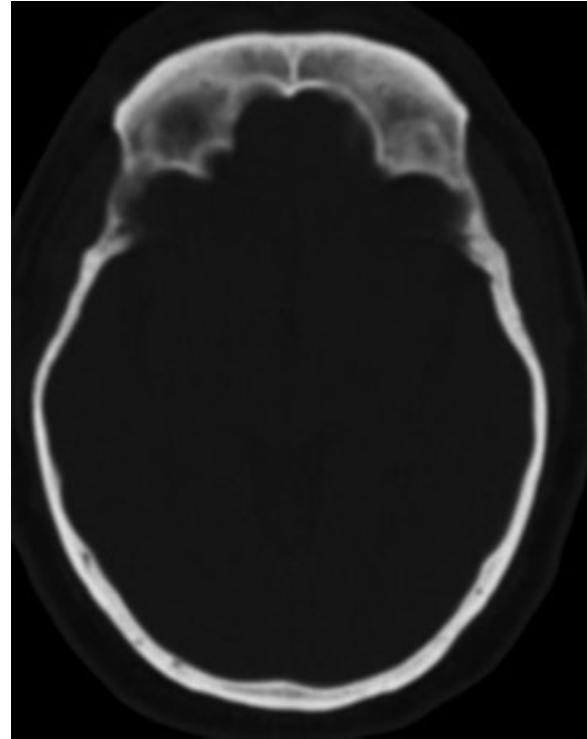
Transverse CT section of skull of patient with LS: Note the absence of frontal sinuses and the developed supraorbital ridges.
